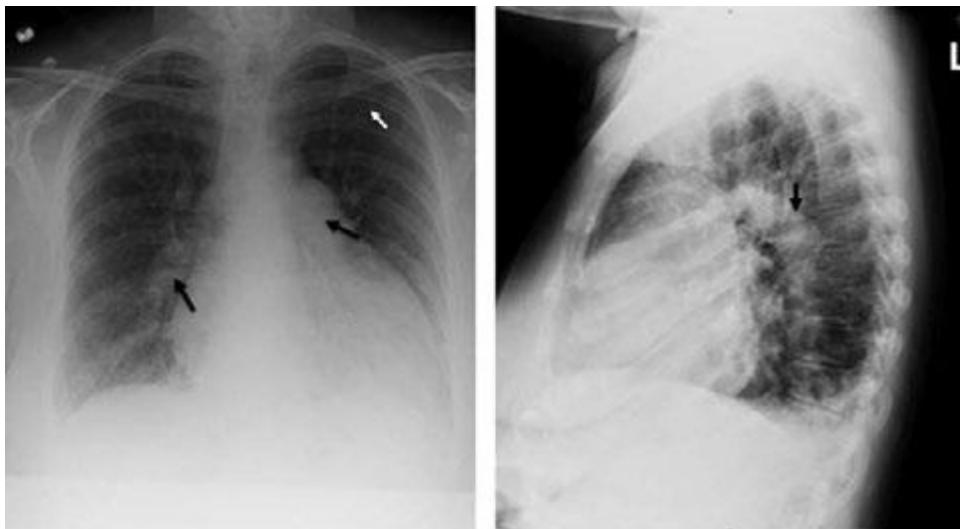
Posteroanterior (left) and lateral (right) chest radiograph showing enlarged pulmonary arteries (black arrows) and pruning of the distal pulmonary vasculature (white arrow) commonly seen with advanced pulmonary arterial hypertension.
